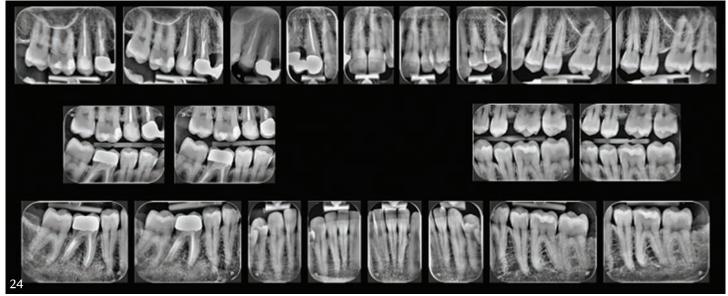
Complete radiographic status
